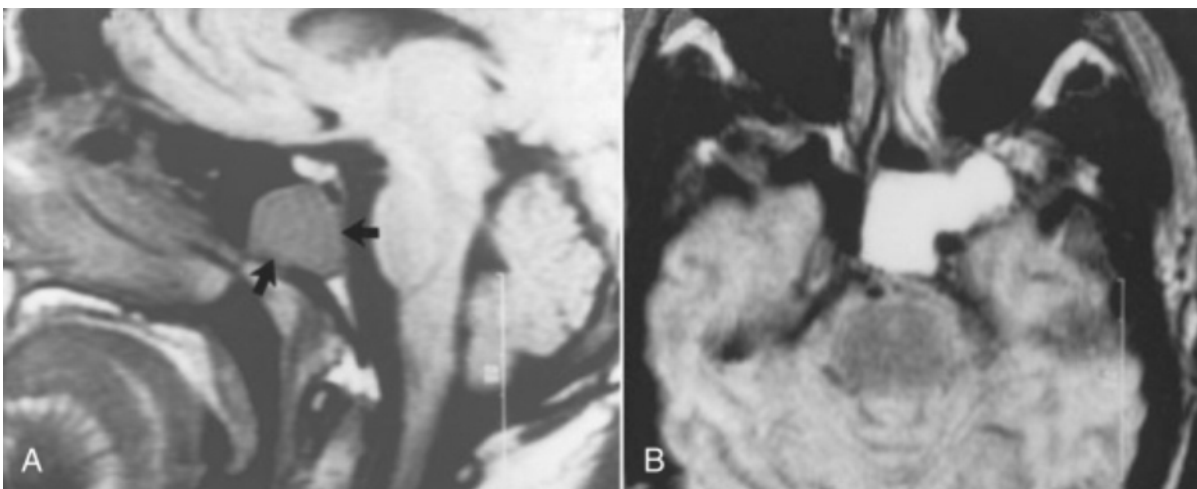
A, A T1-weighted magnetic resonance image demonstrates a sphenoid sinus mass (*arrows*) that is consistent with either a tumor or secretions. B, A T2-weighted image, however, demonstrates high signal intensity consistent with secretions from obstruction of the ostium of the sinus.
